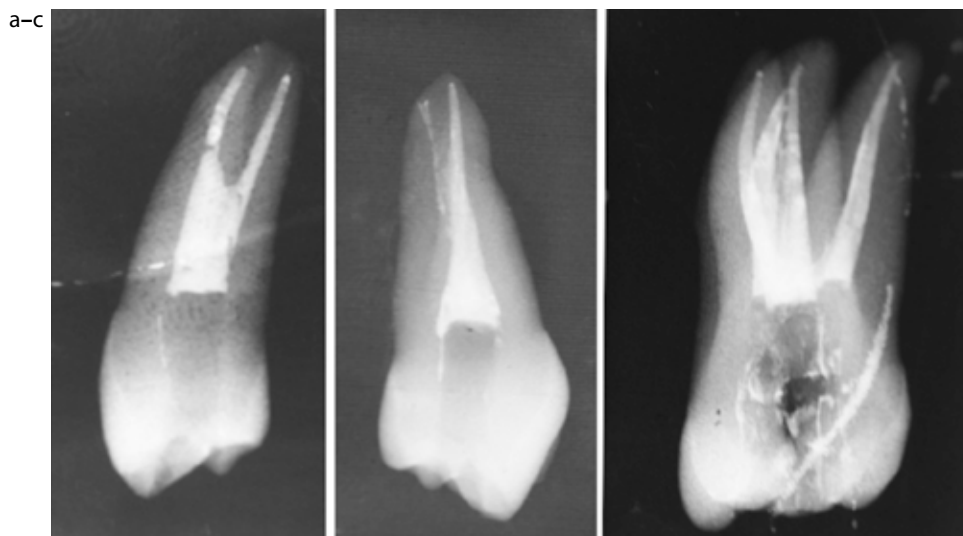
(a–c) Radiographs taken from a lateral view reveal the differences in canal morphology. A conventional radiograph would not have revealed the second canal, leaving a significant portion of the tooth untouched by instruments and failure likely.
